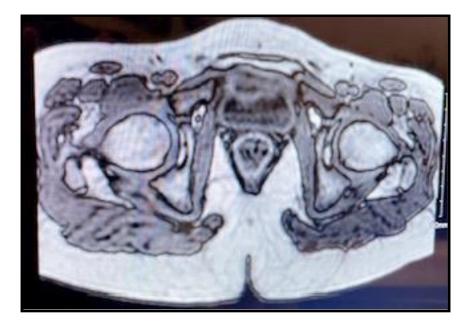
MRI sagittal plane cut showing absence of uterus and ovaries
